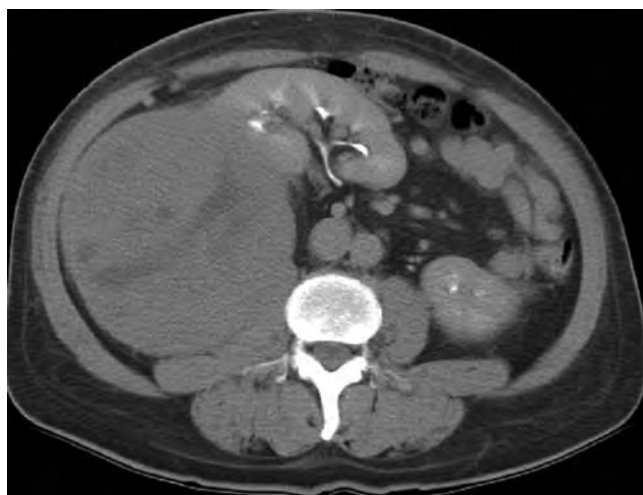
Axial cut in excretory phase of a computed tomography scan demonstrating a large right adrenal carcinoma. The right kidney is shifted anteriorly and medially. Similar-sized masses that arise from the kidney itself usually do not displace the renal unit. Important, even at this large size the adrenal carcinoma appears relatively homogeneous and well circumscribed—features deceptively camouflaging its deadly biologic potential. Surgical resection demonstrated a 25-cm, stage II (pT2N0M0), localized adrenocortical carcinoma. (Courtesy Dr. David Y. T. Chen, Fox Chase Cancer Center, Philadelphia.)
